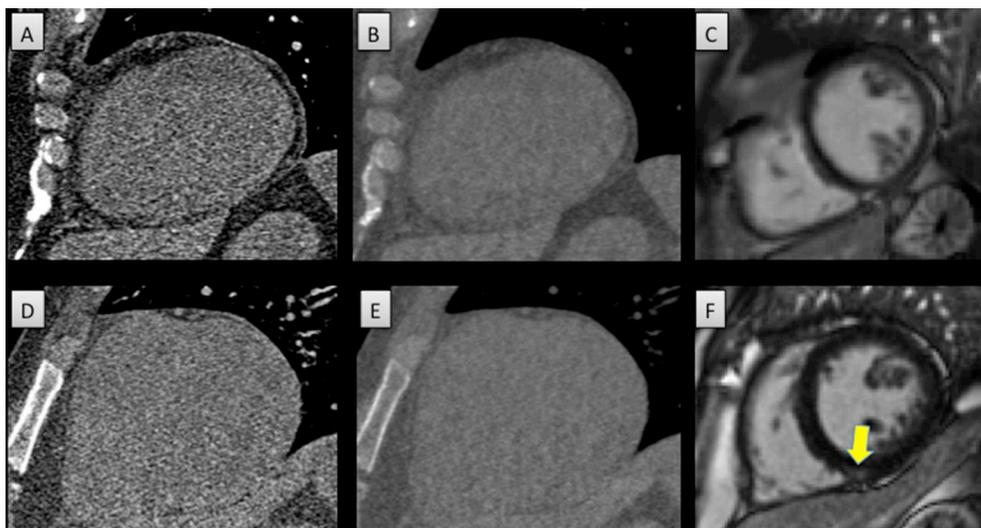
Visual analysis of monochromatic images (e.g. 40 and 120 keV) from dual energy computed tomography (DECT) does not readily distinguish absent (Panels A–C) vs. present (Panels D–F) myocardial fibrosis as seen by late gadolinium enhancement cardiac magnetic resonance (LGE-CMR).
